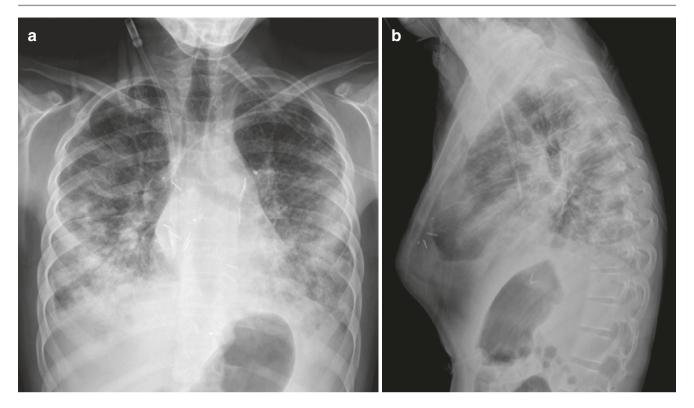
Pectus carinatum in a patient with cystic fibrosis. (a) Frontal radiograph shows multifocal opacities representing infection. (b) Lateral chest radiographs demonstrate protruding sternum
